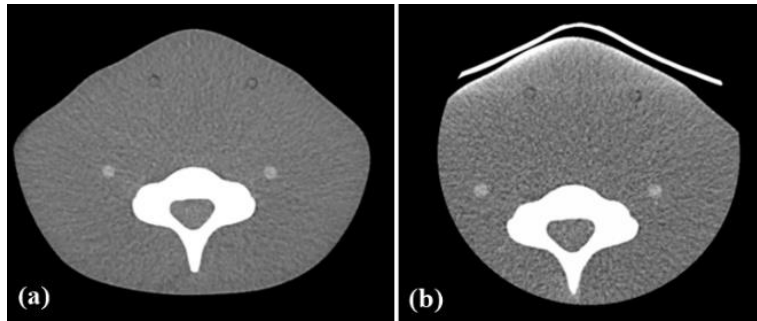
Axial neck CT images: without (a) and with bismuth shielding (b) on the neck.
